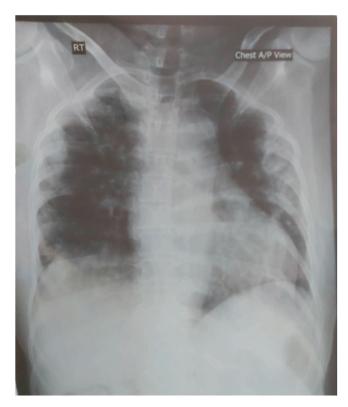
Chest X-ray posterior-anterior view on admission(24 June, 2020) showing bilateral extensive pulmonary infiltration mostly in the periphery of both lungs.
